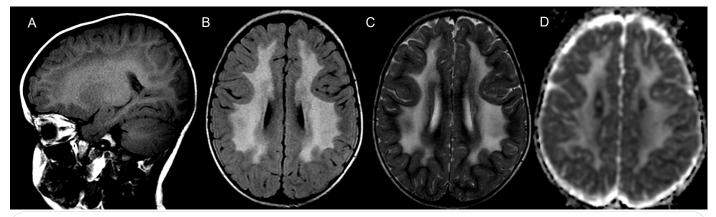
Sagittal T1-weighted image (A) shows hypointensity of the subcortical white matter. Axial FLAIR and T2-weighted images (B&C) reveal extensive symmetrical hyperintensity compromising profound and periventricular white matter of the cerebral hemispheres. Axial ADC map (D) demonstrates small areas of restricted diffusion within the signal abnormality.
